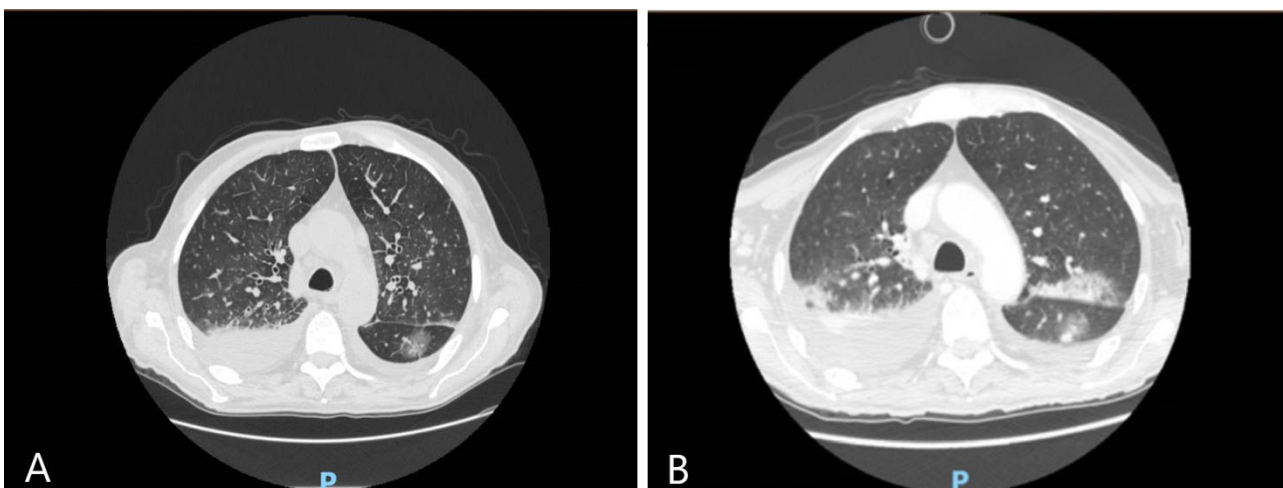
Thoracic CT scan with contrast enhancement at admission (A) and on day 25 of hospitalization (B).
